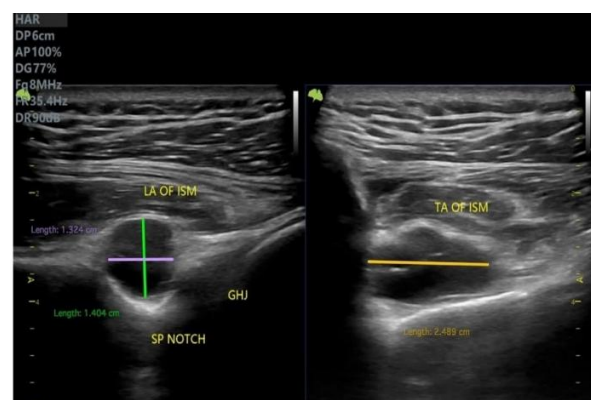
An ultrasound of the spinoglenoid cyst: hypoechoic thin septate -measures 1.3cm × 1.4 cm along the longitudinal axis (LA) of infraspinatus muscle (ISM), and measures 2.48cm along transverse axis (TA) of ISM.
